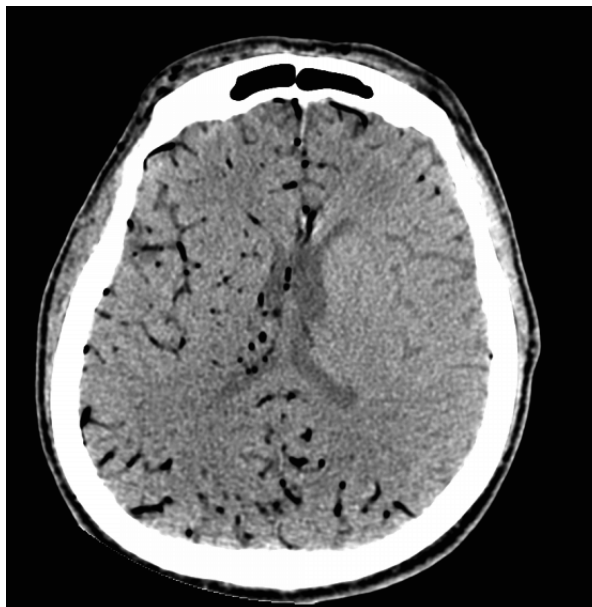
Brain CT. On axial CT, scan shows brain vessels with low density that indicates intravascular pneumocephalus
